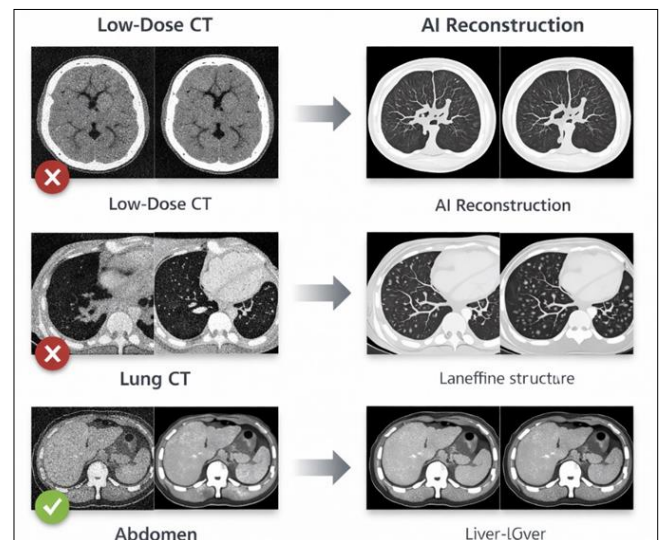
comparison of low dose CT images before and after AI based reconstruction
